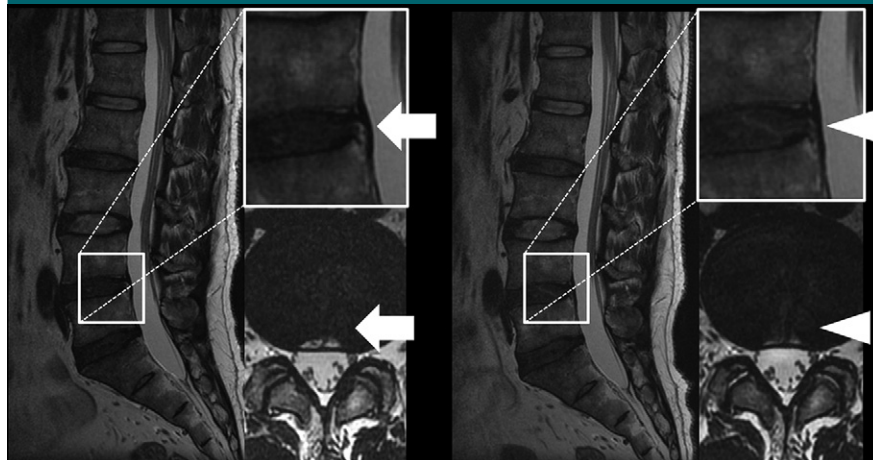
MR images show reduction of the HIZ at the posterior annulus before traction (left) and 30 minutes after traction (right). The HIZ at the posterior annulus is observed, and the disk shape is convex (arrows) prior to traction. The HIZ has been reduced at the posterior annulus 30 minutes after traction and reabsorbed into the nucleus (arrowheads). The convexity of the disk has also disappeared. Reduction of the HIZ is also seen in axial views (lower right images).
